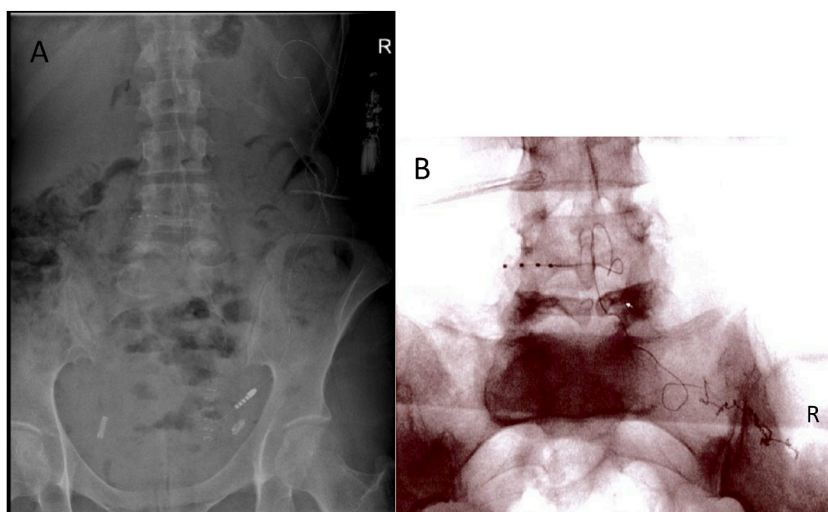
(A) Preoperative lumbar X-ray showing displacement of the IPG in left flank with the tip of the electrode paramedian right at L4-L5. (B) Perioperative lumbar X-ray showing coiling of the wires and displacement of the lead.
